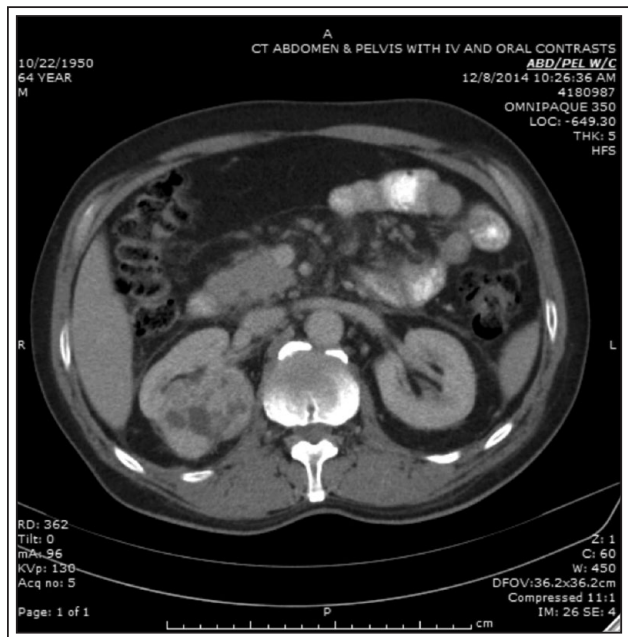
CT demonstrating a large, heterogeneous, enhancing right renal mass.
